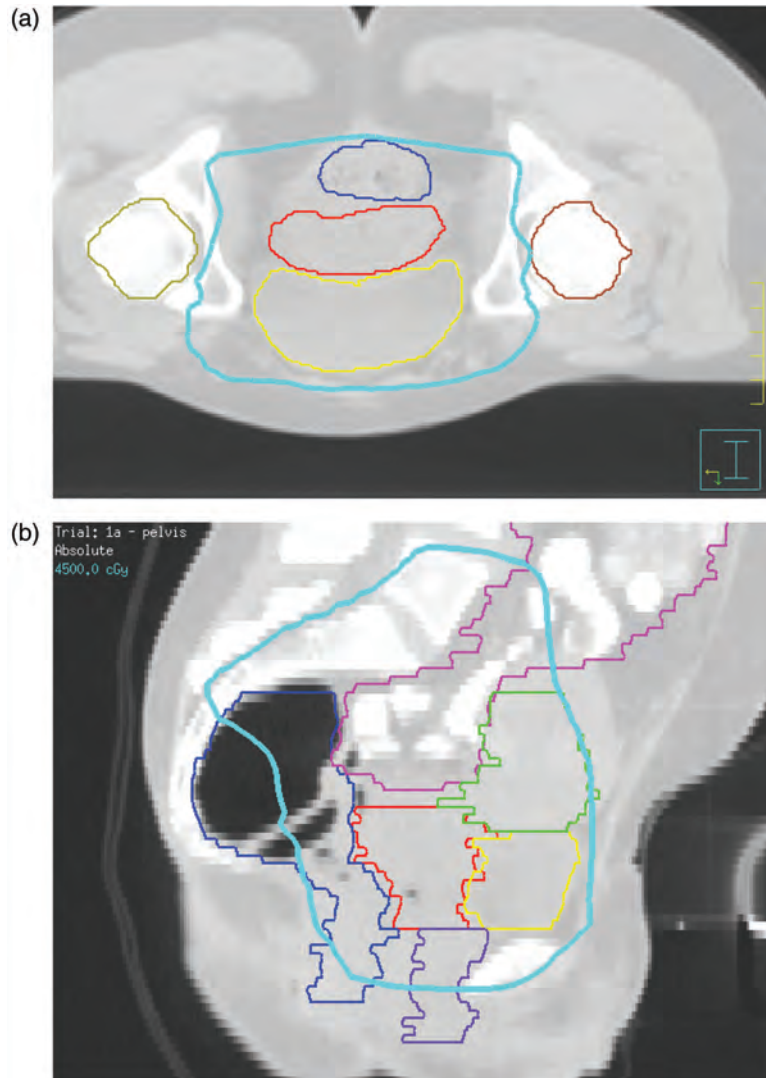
Dose distribution of external-beam pelvic radiotherapy: (a) transverse and (b) sagittal. The GTV and cervix is shown in red based on the PET–CT findings (confirmed by MRI), the bladder in yellow, the rectum in blue, the right femoral head in brown, the left femoral head in gold, the uterus in green, the small bowel in magenta, and the vagina in purple. The PTV encompassing the 45 Gy volume is shown in cyan.
